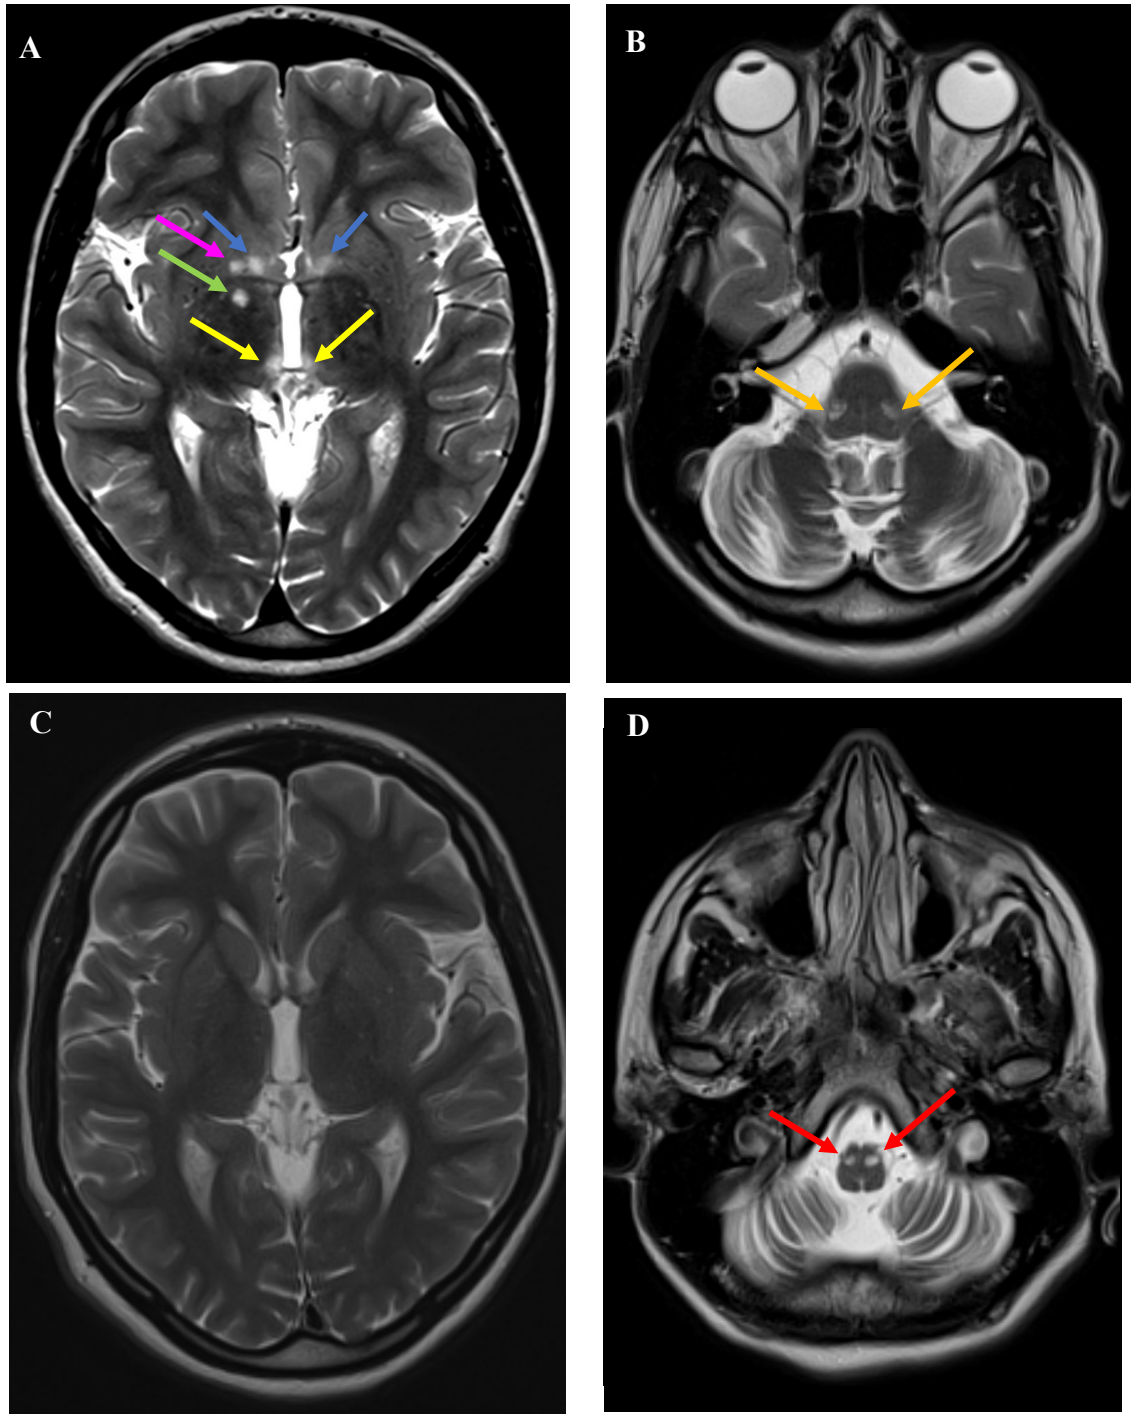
Brain MRI Neuroradiological Images of Patient 24-I
